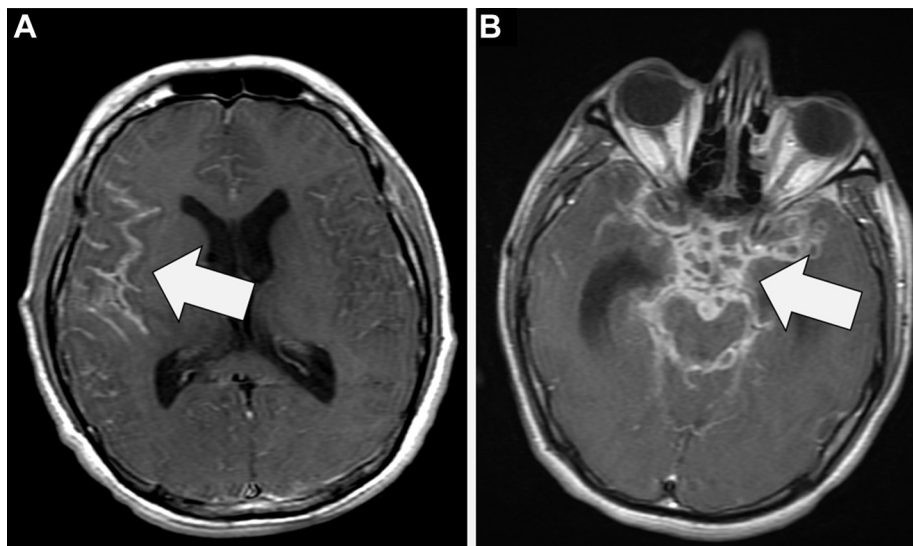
T1-weighted MRI of the brain with gadolinium demonstrating (A) bilateral basilar leptomeningeal enhancement (white arrow) at the time of presentation; and (B) interval development of multiple hypodense lesions after initiation of therapy.
